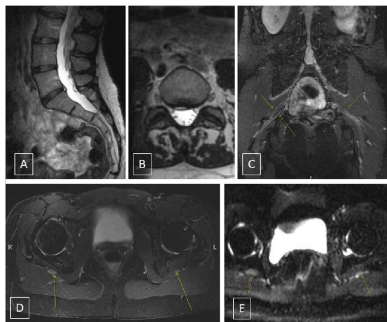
Piriformis syndrome: 52-year-old woman with right leg pain and partial foot drop for 2 years. Outside MRI L spine reported negative.
